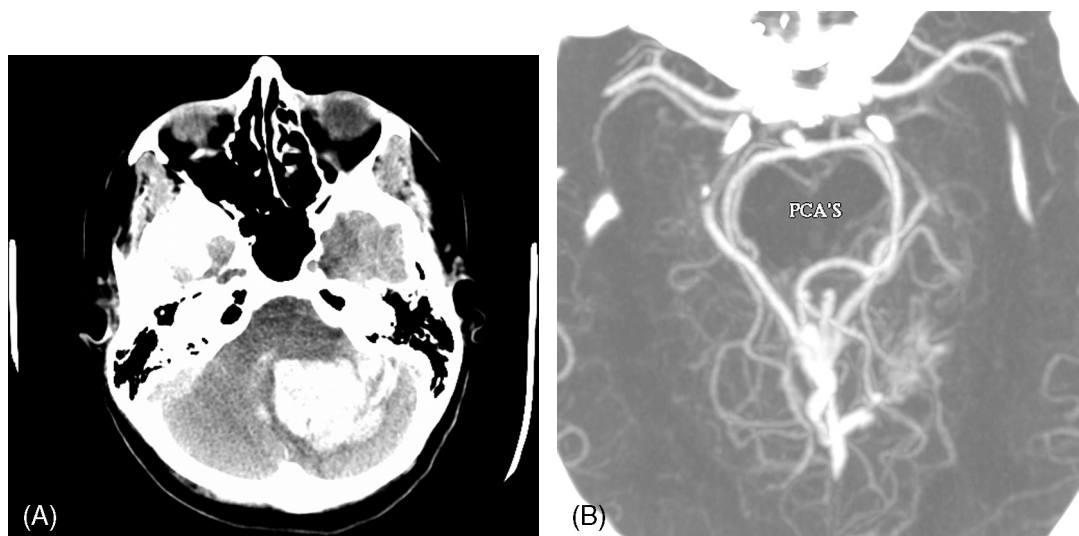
Arteriovenous malformation. A 32-year-old woman, 17 weeks pregnant, developed a sudden severe headache. (A) Non-contrast head CT shows an intraparenchymal hemorrhage in the left cerebellar hemisphere. (B) CT angiogram reconstruction reveals an underlying arteriovenous malformation.
